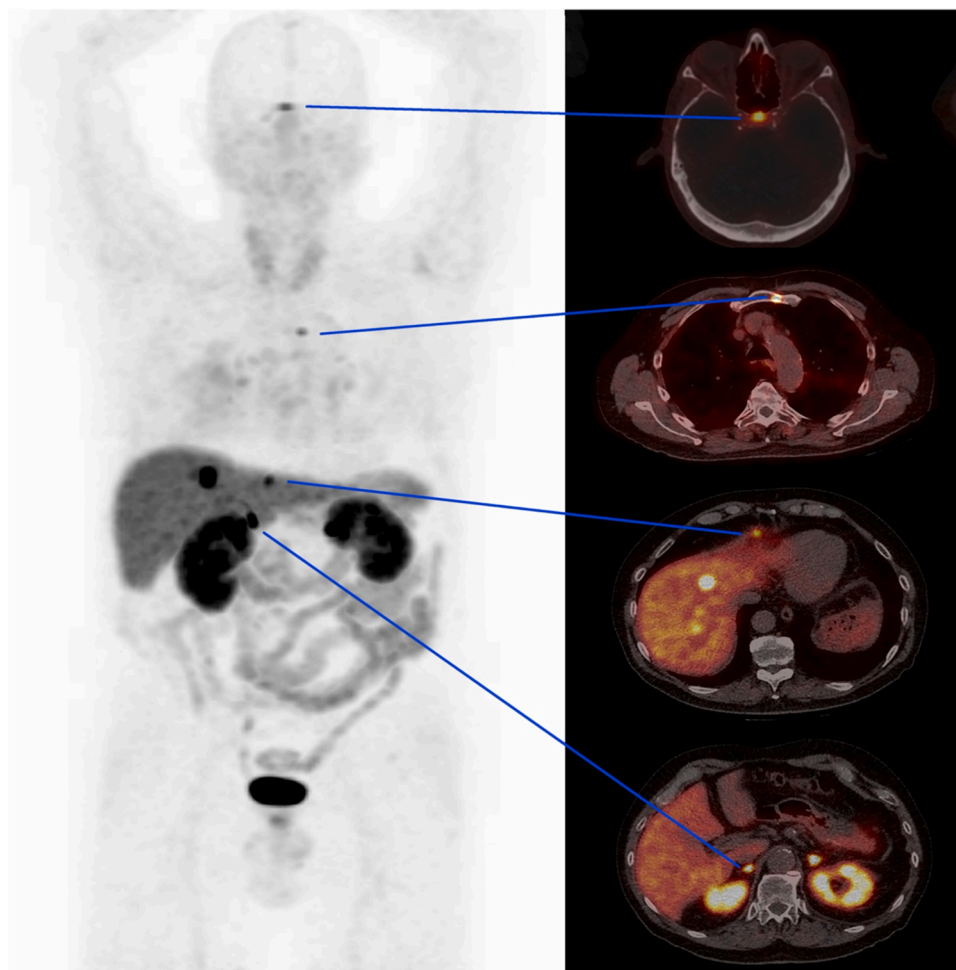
70-year-old male with a history of partial pancreatectomy for NET G2, now referred for follow-up with ^{68}Ga -DOTATOC PET/CT. Left panel: Maximum intensity projection (MIP) of ^{68}Ga -DOTATOC PET/CT. Right panel: Transverse cross-sectional PET/CT images at various levels. Blue lines connect areas of ^{68}Ga -DOTATOC uptake on MIP with the same lesion on the corresponding transverse section. Upper blue line: Physiological uptake in the hypophysis. Second blue line: Bone metastasis in the sternum. Third blue line: Two metastases in the liver. Bottom blue lines: Physiological uptake in the right adrenal gland.
